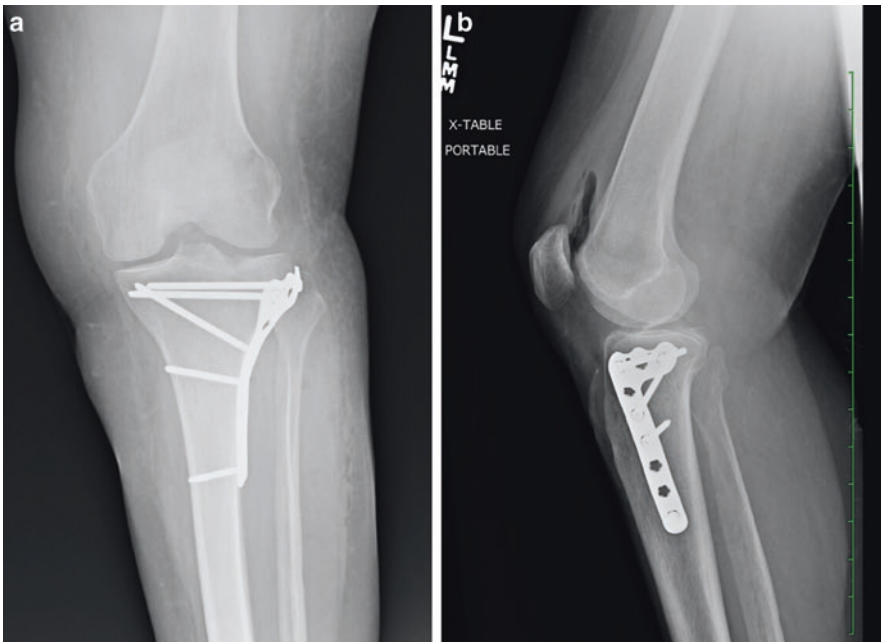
(a) Postoperative AP radiograph of the left knee (b) Postoperative lateral radiograph of the left knee
